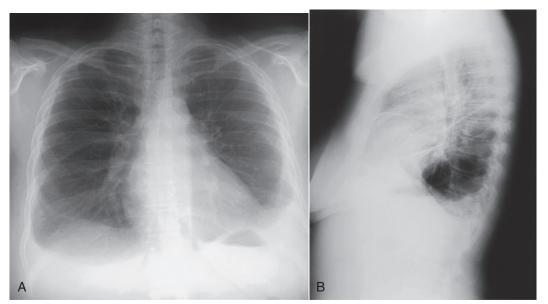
Pleural Effusion. Posteroanterior (A) and lateral (B) chest x-rays in a 43-year-old patient with long-standing bilateral pleural effusions resulting from rheumatoid arthritis. Note that the bilateral meniscus sign is also visualized posteriorly on the lateral view.
